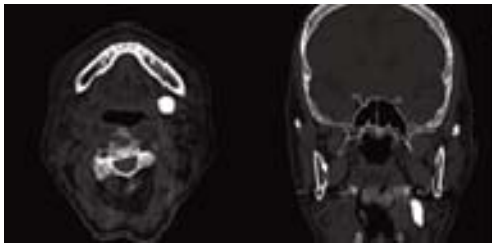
CT showing a large radiopaque mass in the left submandibular region.
